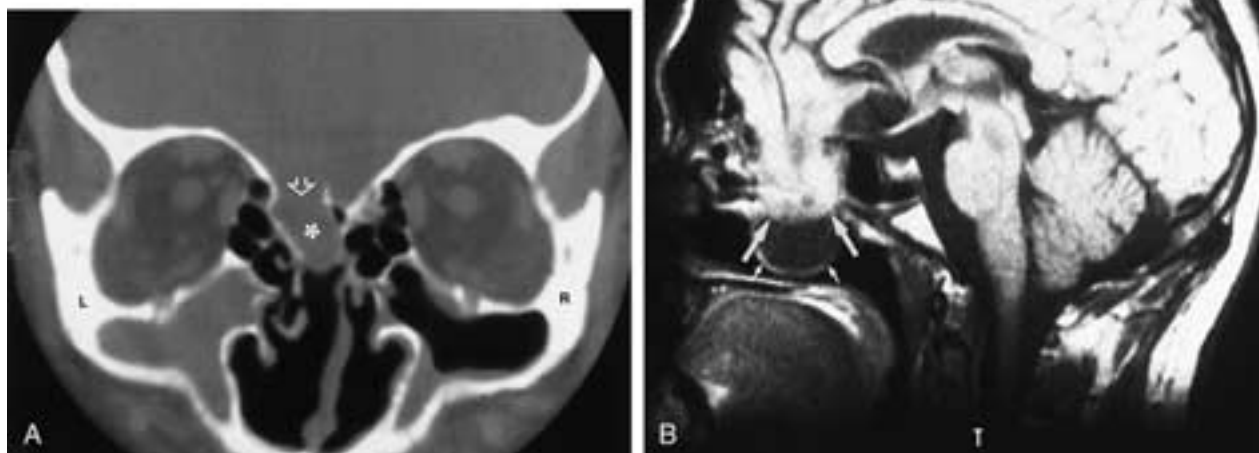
CT and MR imaging display of an encephalocele. Coronal CT image (A) through the posterior ethmoid sinus shows erosion of the roof of the posterior ethmoid sinus (*open arrow* and *asterisk*). Axial T1-weighted MR image (B) shows an isolated soft-tissue mass within the posterior ethmoid sinus (*arrow*), which on the coronal T1-weighted MR image (C) is confirmed to be an encephalocele. Gyrus rectus (*r*) and gyrus orbitales (*o*) are noted.
